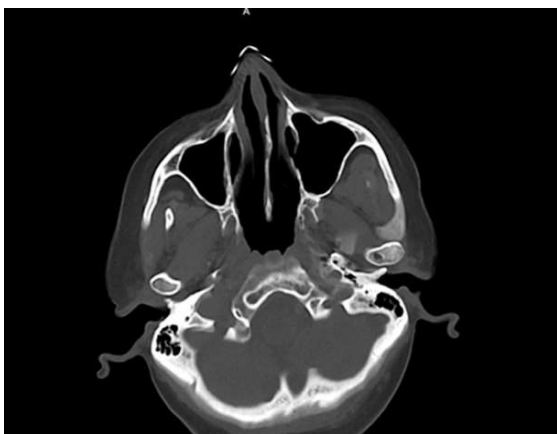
CT Scan image of sinus of coronal view
